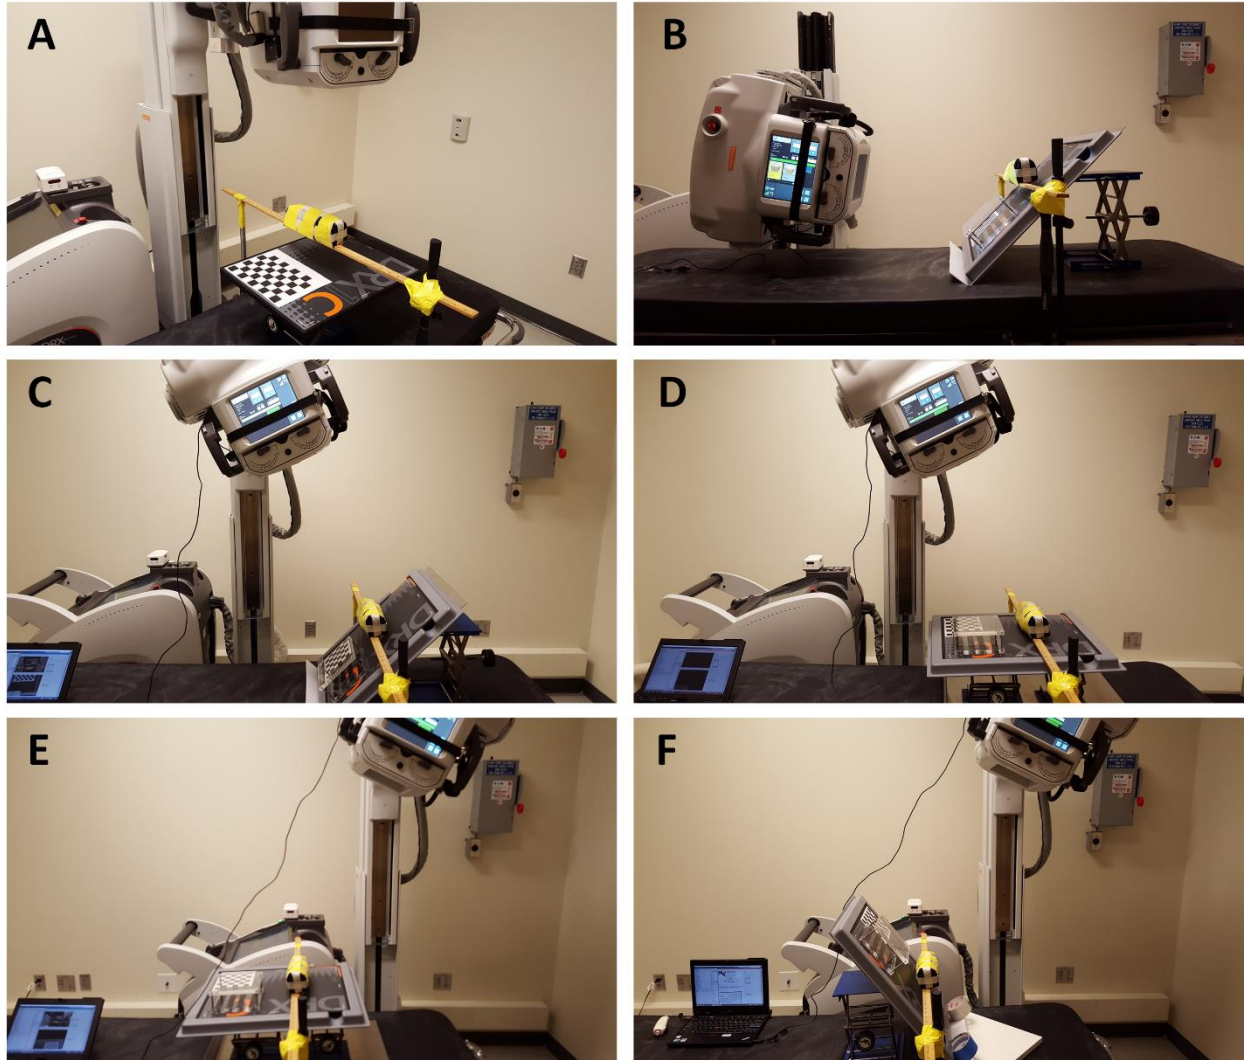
A) Free form CT imaging setup with the object rigidly attached to not move during the process to a low attenuating rod (meter stick). B) Imaging begins at the left side. C) Reaching the limit of this detector position. D) Source is stationary, the detector is moved to preserve the coordinate system. E) Imaging continues to the right-most side with the detector flat. F) Source is stationary, the detector is moved once again and the imaging can continue to the right side.
